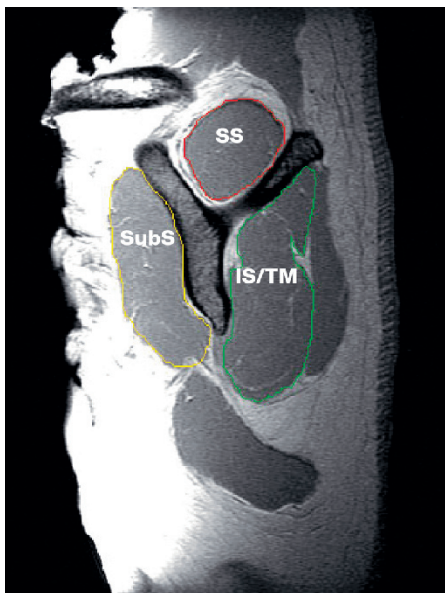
MRI scan of the left shoulder. The image is at the site of the Y-shaped position (Method 1). Rotator cuff muscles have been contoured, using three-dimensional image analysis software.
